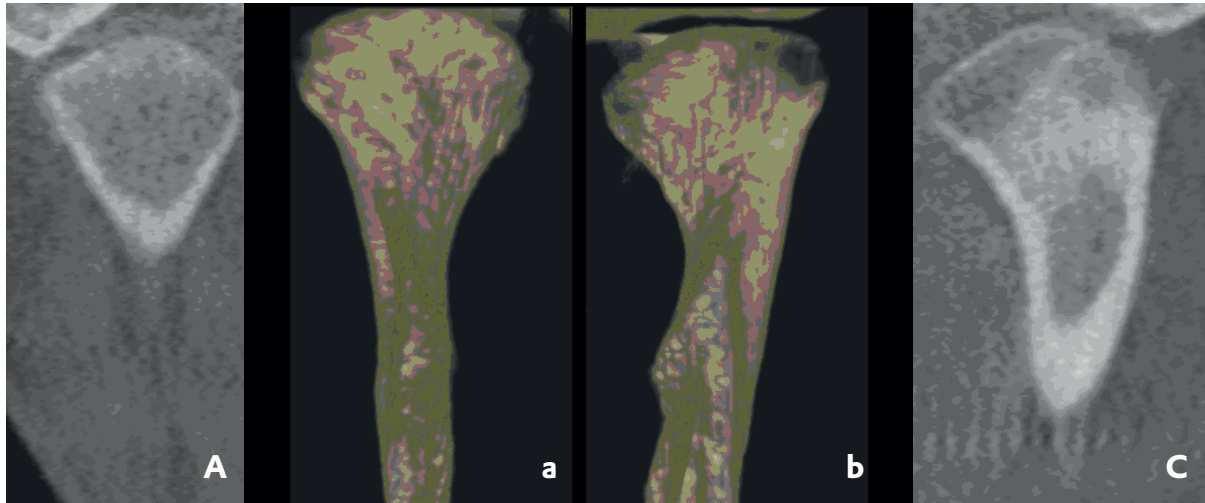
Fig - CBCT and reconstructed image of condyles
